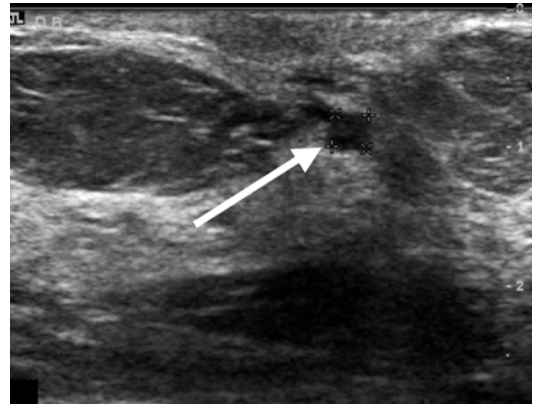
Subareolar ultrasound demonstrating a 0.35 cm intraductal lesion (arrow) in a patient subsequently found to have ductal carcinoma in situ upon subareolar duct excision
